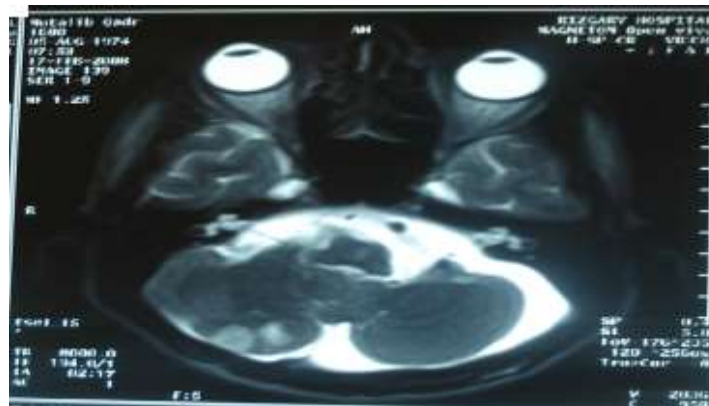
MRI in T2WI axial shows right posterior cerebellar infarction, giant cisterna magna and asymmetry and atrophy of cerebellum and brain stem
